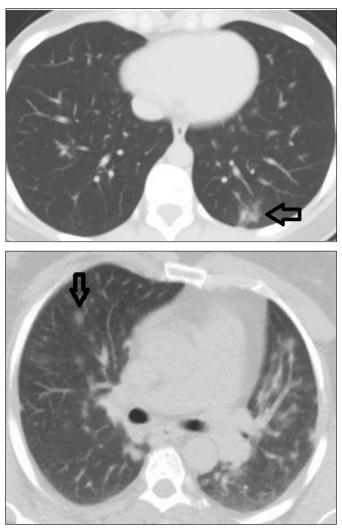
a. Axial unenhanced chest CT image of 35 year old patiet with Wuhan Type COVID-19 pneumonia shows peripheral GGOs b. Axial unenhanced chest CT image of patient with infected with B.1.1.7 variant shows noduler and patcy GGOs in central peribroncovascular area.
